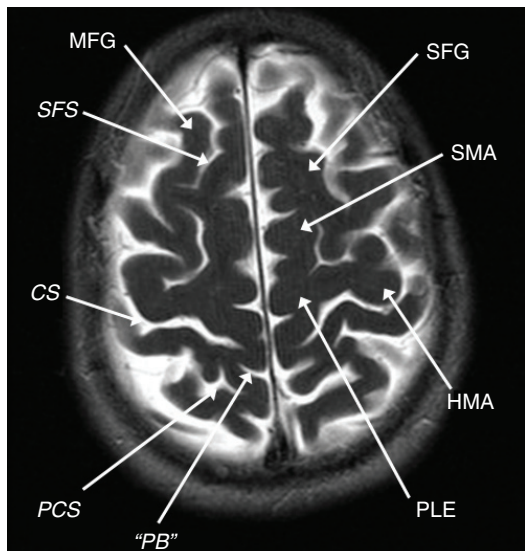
Axial T2-weighted MRI showing the middle frontal gyrus (MFG), superior frontal gyrus (SFG), superior frontal sulcus (SFS), central sulcus (CS), supplementary motor area (SMA), postcentral sulcus (PCS), pars bracket (PB), hand motor area (HMA), and proximal leg area (PLE).
